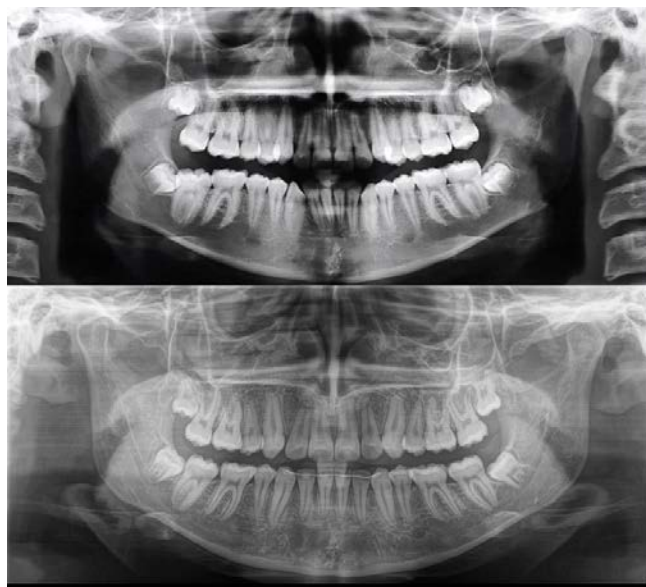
Pre- and post-treatment orthopantomograms of a patient treated with the extraction of the upper first and lower second premolars
